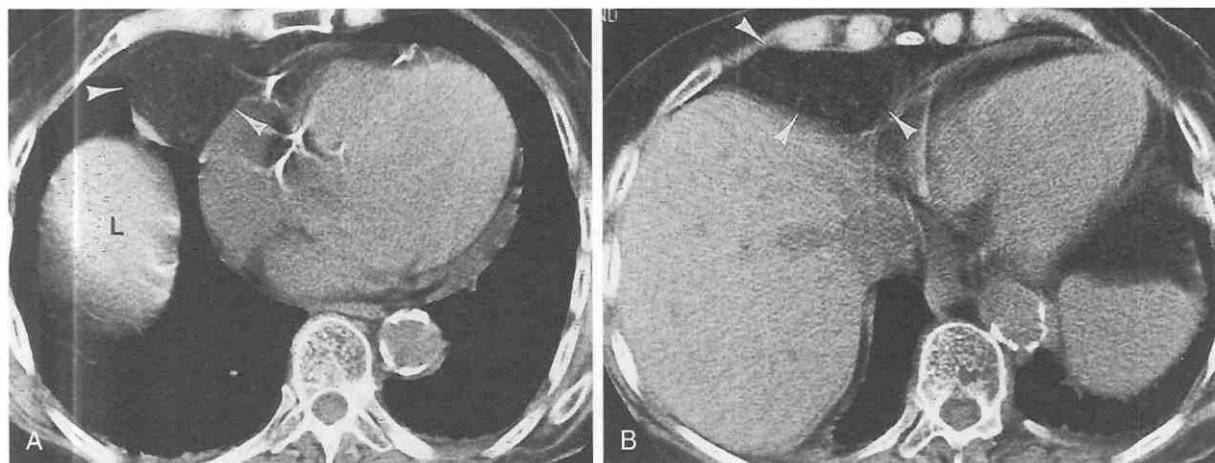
Morgagni's hernia. A and B, CT shows herniation of omental fat (arrowheads) into the right cardiophrenic angle. Omental vessels are seen within the fat. L, liver.
